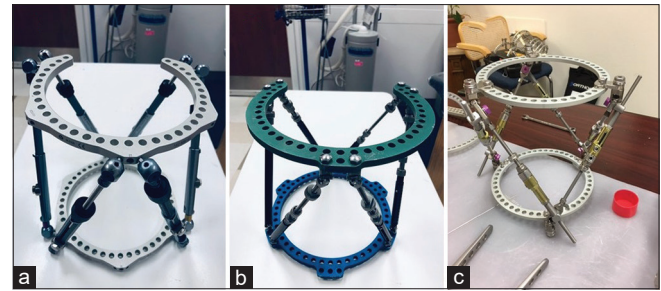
Ring fixator systems. (a) TL-Hex (Orthofix). (b) Taylor spatial frame (Smith and Nephew). (c) Ortho SUV frame (Ortho-SUV Ltd)
